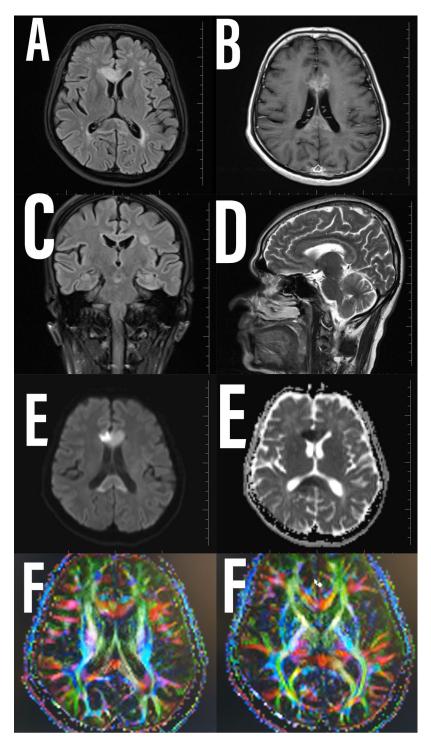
(A) FLAIR Axial (C) FLAIR Coronal (D) T2 sagittal images shows that the involvement of the corpus callosum has extended anteriorly involving the body and the head of the corpus callosum. Previously involved posterior corpus callosum and the splenium show central necrosis. (B) Contrast images reveal mild Gadolinium contrast enhancement of the lesions. DTI images demonstrate loss of integrity and the volume of the transverse fibers of the posterior corpus callosum.
